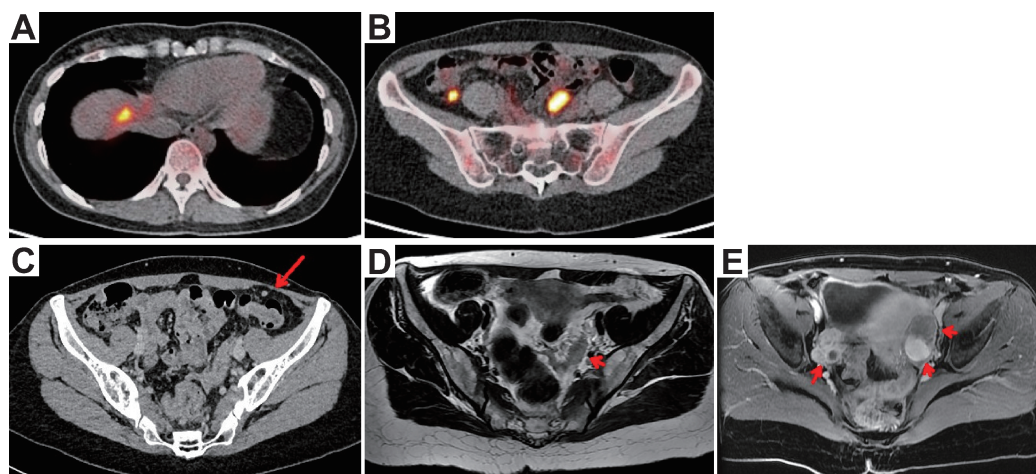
Positron emission tomography/computed tomography (PET-CT), contrast-enhanced CT, and magnetic resonance imaging (MRI) before surgery
